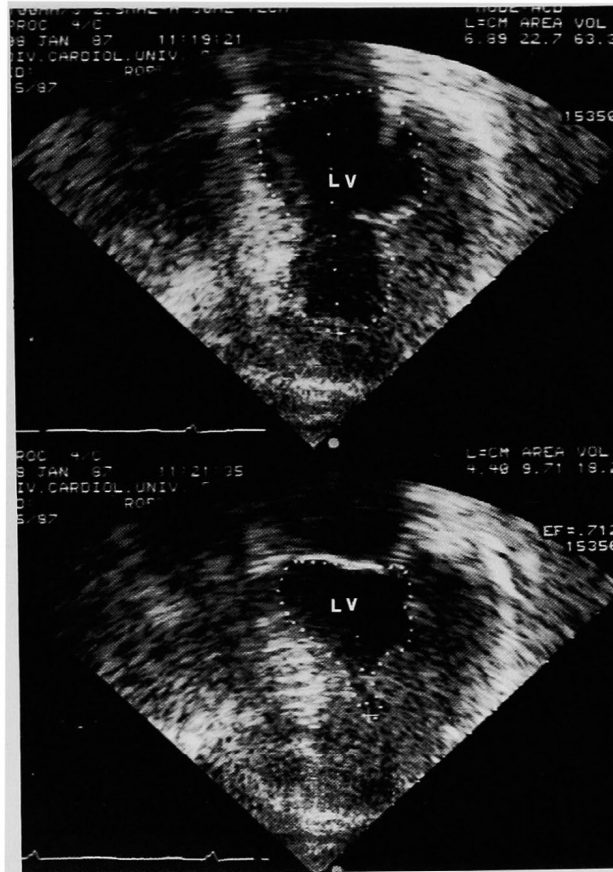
Two-dimensional echocardiograms in patient 1. The apical four-chamber view shows a non-obstructive cardiomyopathy. Upper panel: diastolic frame. Lower panel: systolic frame. LV=left ventricle.
